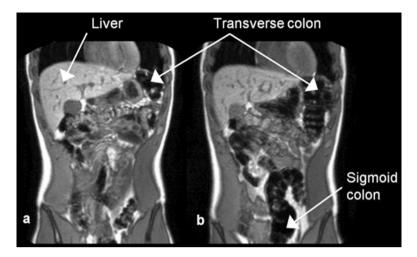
The image on the right shows large amounts of gas (seen as black because it provides no MRI signal) in the colon of a subject who was fed a drink of inulin. The image on the left shows the corresponding image at baseline where little gas can be seen. Reproduced with permission from Murray et al. (2014)
